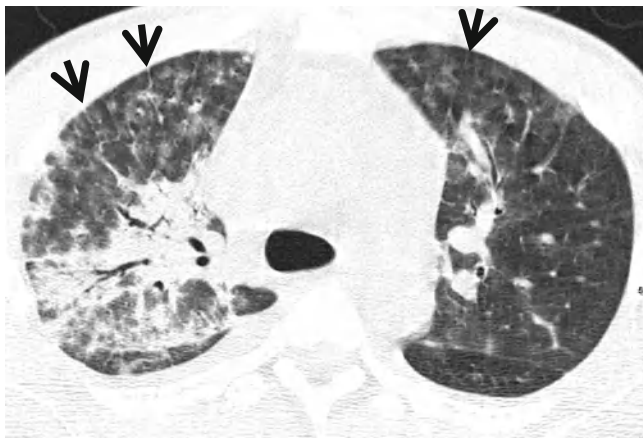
Acute lupus pneumonitis in a 47-year-old woman with systemic lupus erythematosus. Lung window image of CT scan (2.5-mm section thickness) obtained at level of azygos arch shows patchy and extensive areas of parenchymal opacity in upper lung zones. Also note mild and smooth thickening of interlobular septa (*arrows*)
